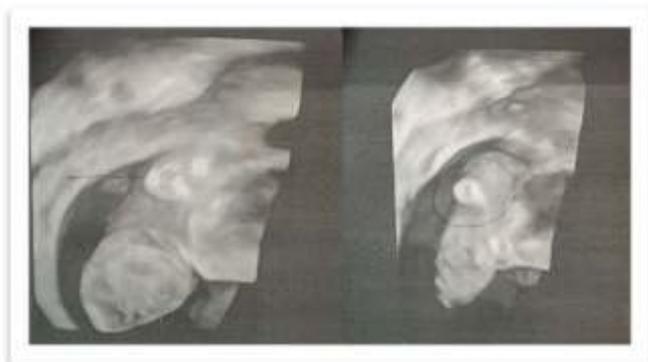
Ultrasound of the fetus's Spina Bifida Occulta.
